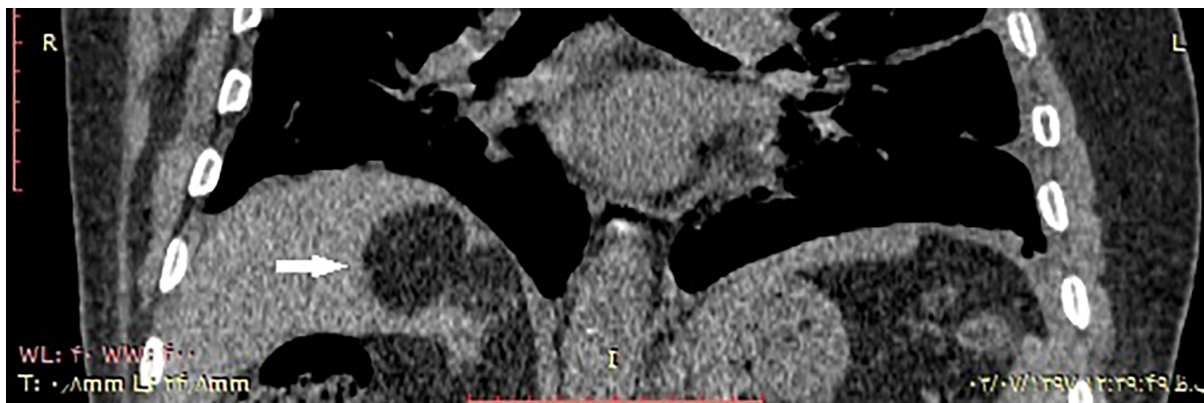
Coronal CT image of liver lipomas in the upper posterior segment
